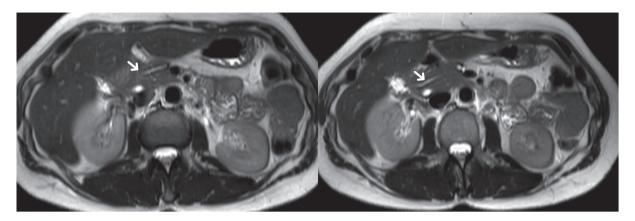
Pancreas Divisum. MR image shows the dorsal pancreatic duct (white arrow) crossing anteriorly to the common bile duct, towards a different drainage site: the minor duodenal papilla.
